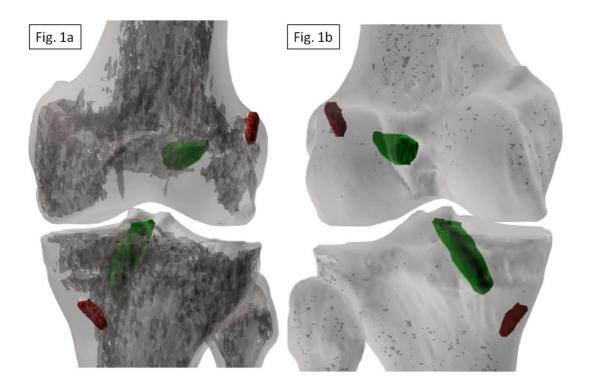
CT images of all patients were exported to an image analysis software (Mimics v1.6, Materialise, Leuven, Belgium) and a manual segmentation of the bone structures, bone tunnels and fixation devices was performed, allowing for the creation of a specific 3D bone model of the knee joint for all patient (1a, left knee, anterior view of an all inside technique; 1b, left knee, posterior view of an all inside technique; 1b, left knee, posterior view of an all inside
